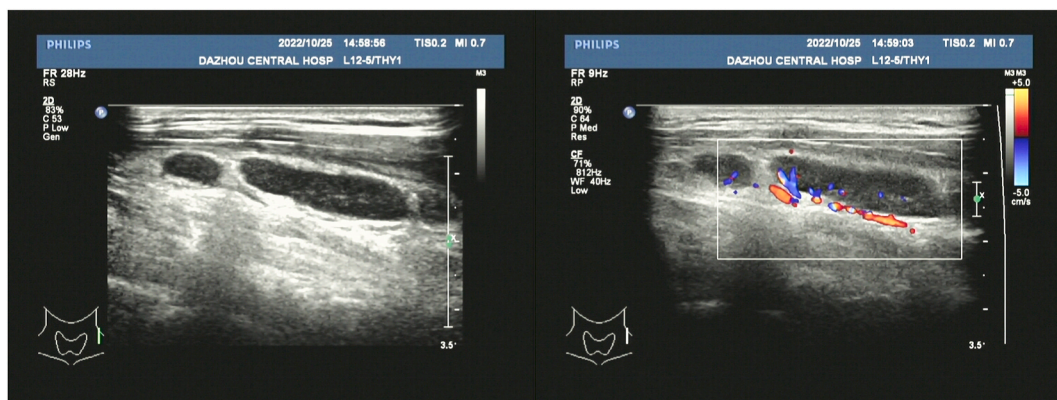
Cervical lymph node color ultrasound before treatment (left). Lymph node ultrasound can be seen in bilateral neck echoes of multiple lymph nodes, cortical thickening, part of the cortical medulla structure is blurred, the left side is about 28.7mmx6.8mm, the right side is about 23.0mmx9.9mm, CDFI: the blood flow signal in the lymph node is abundant; Ultrasound: bilateral cervical lymph node enlargement (slightly structurally abnormal).
